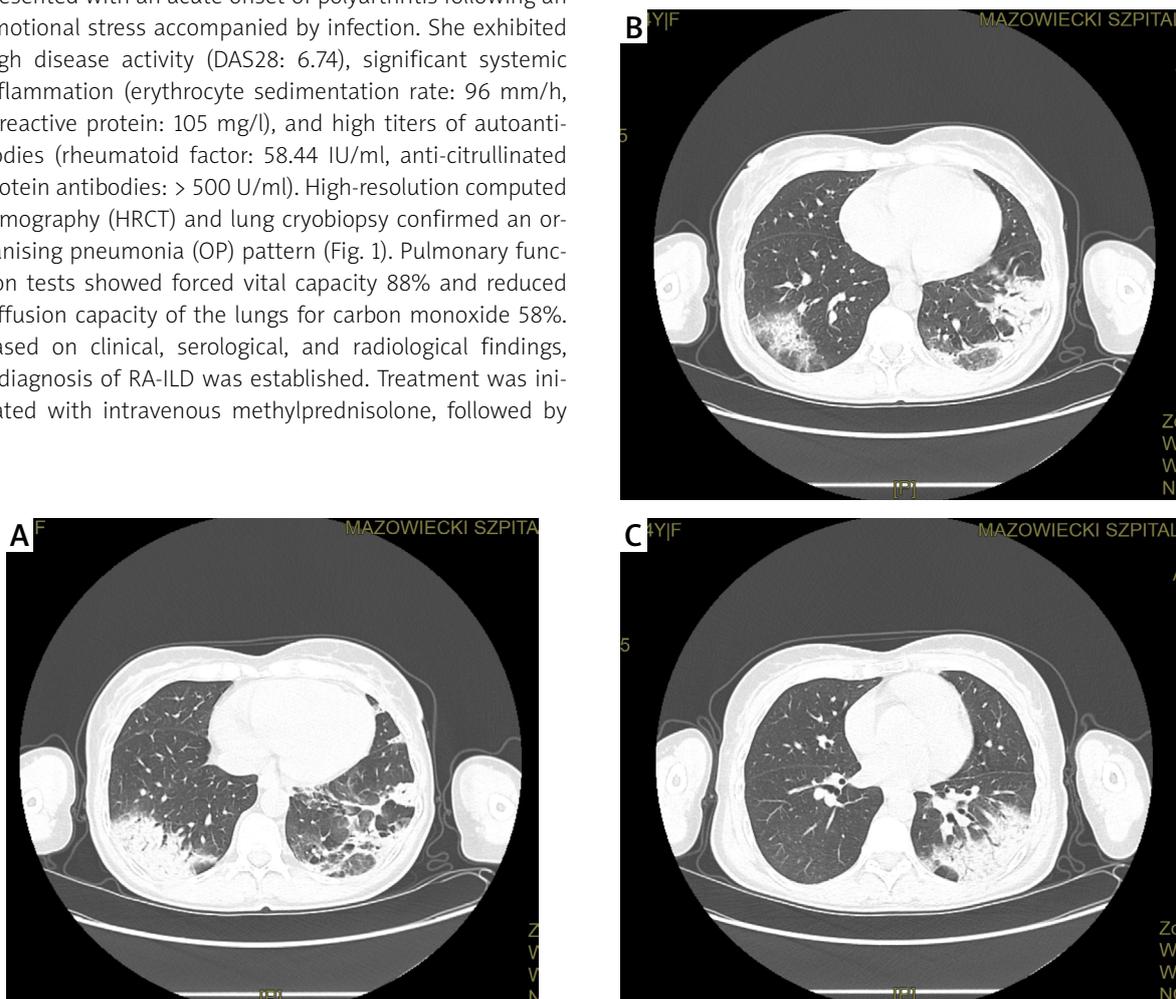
High-resolution computed tomography of the chest showing extensive patchy consolidations and ground-glass opacities with air bronchograms accompanied by diffuse bronchial wall thickening and enlarged mediastinal and axillary lymph nodes.
